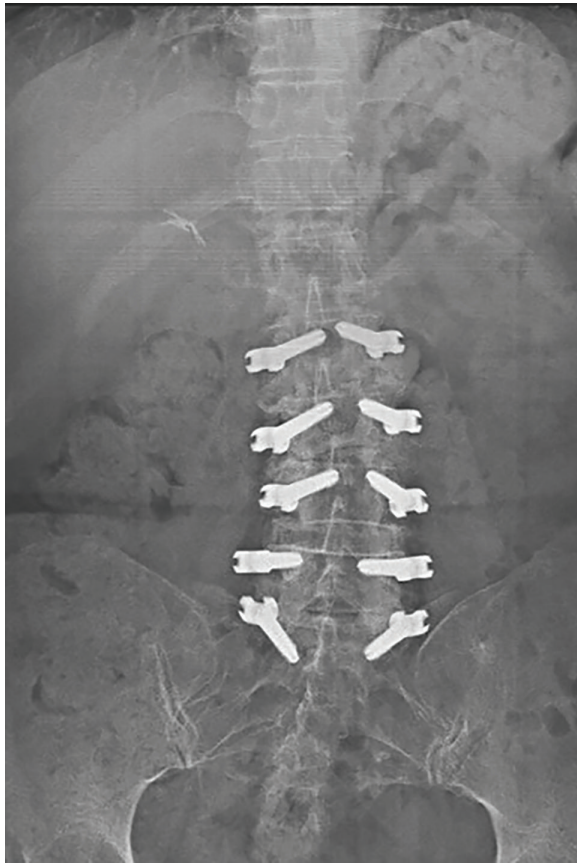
Anteroposterior x-ray image after surgery.
